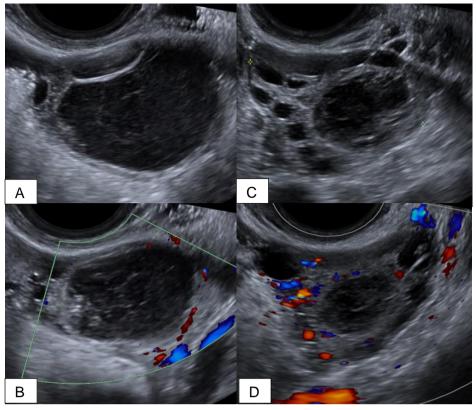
Female patients between 19 and 30 years of age, presented to the emergency department reporting pelvic pain for hours of evolution. Images A and C show a B-mode transvaginal ultrasound, where an ovoid morphology image is identified, hypoechogenic and heterogeneous, with an internal reticular pattern; same that after the application of color Doppler (image B and D respectively) show an absence of flow, findings compatible with hemorrhagic ovarian cyst.
